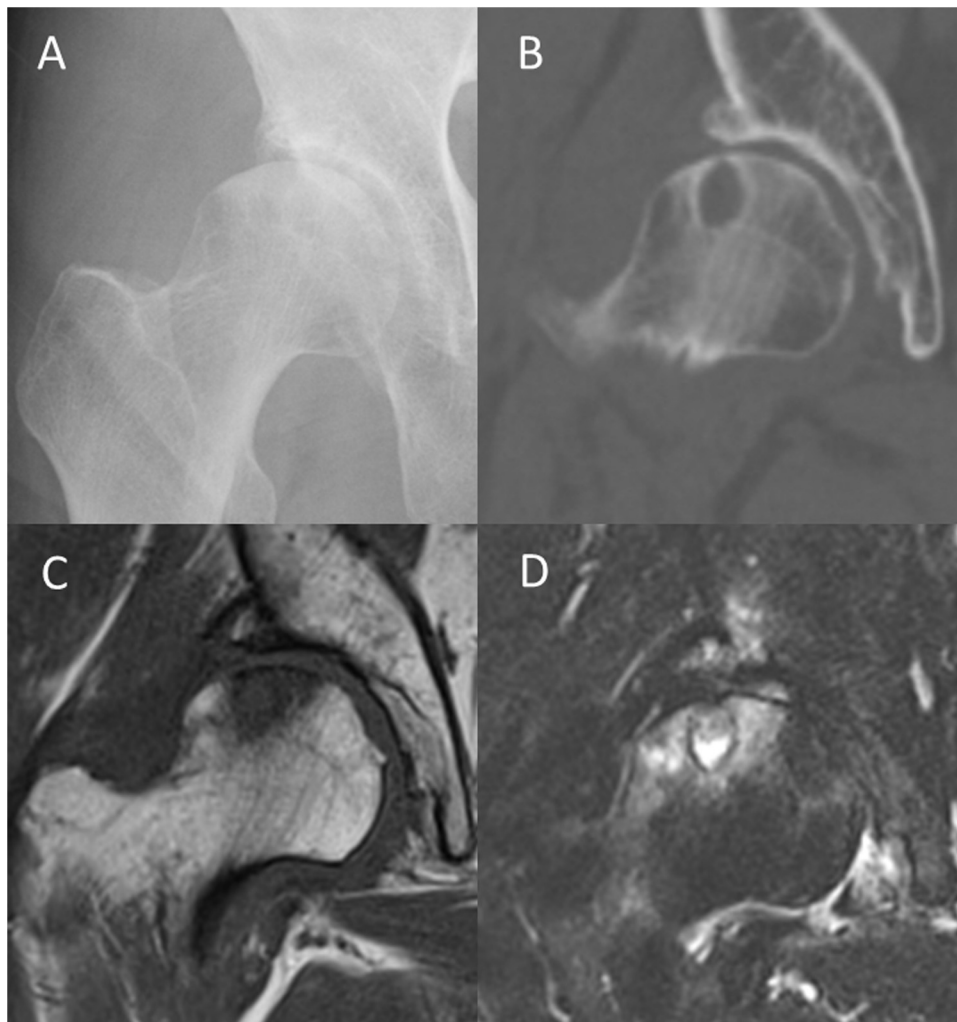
Images obtained 2 months after the onset of hip pain: (A) radiograph showing no remarkable changes in the joint space. (B) Computed tomography multiplanar reconstruction showing a lytic lesion with a well-defined sclerotic margin in the superolateral portion of the femoral head. (C) Coronal T₁-weighted magnetic resonance image showing diffuse low signal intensity in the superolateral portion of the femoral head and acetabular rim. (D) Corresponding area of high signal intensity on the short τ inversion recovery (STIR) sequence. On the femoral side, there is a very high signal intensity area on the STIR sequence as well. A well-delineated round, low-intensity band is also visible on the T₁-weighted image and the STIR sequence.
